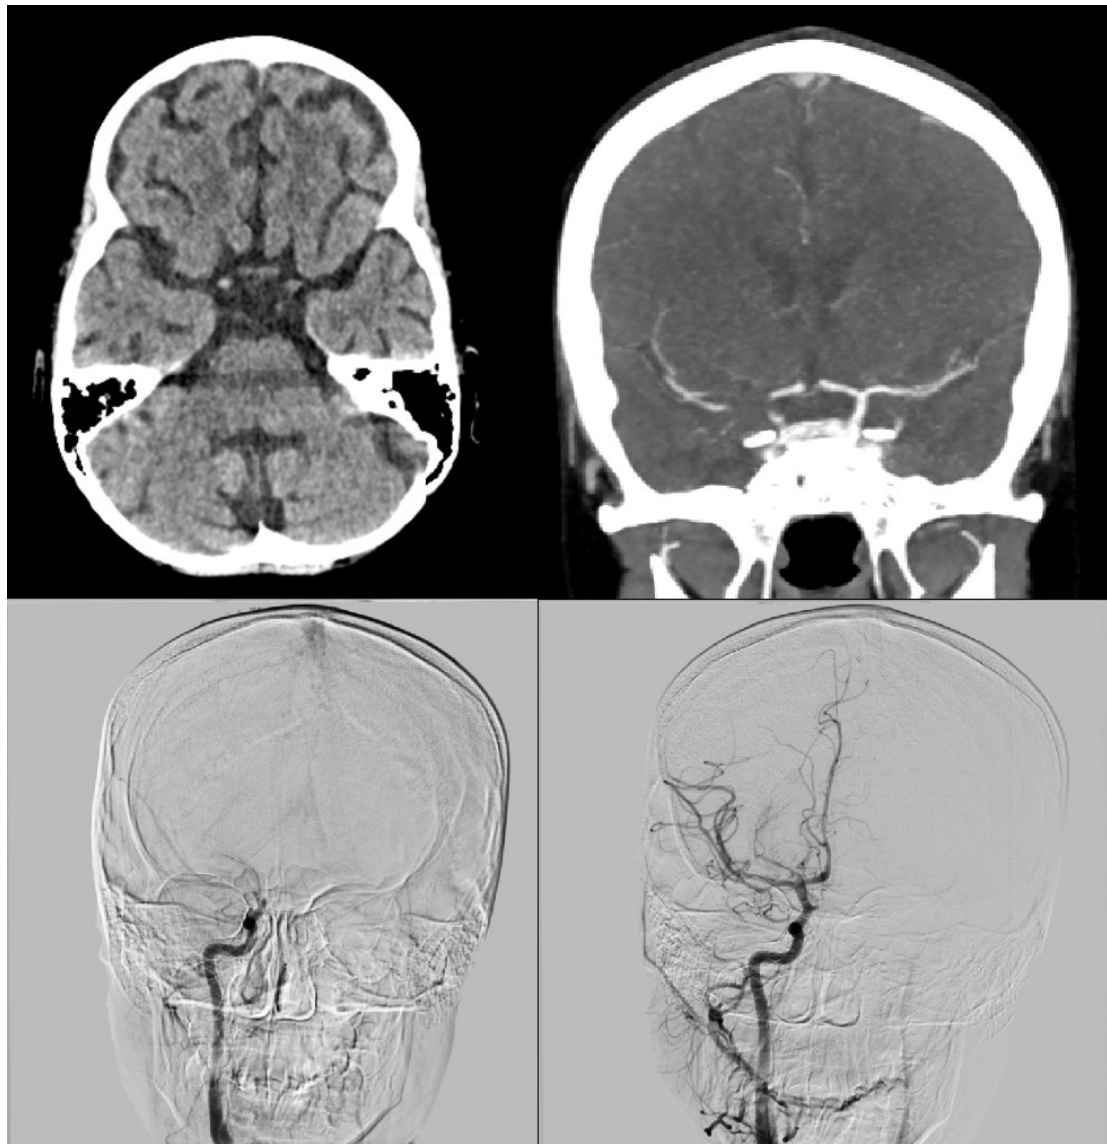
Mechanical thrombectomy procedure during ventricular assist device (VAD) support. Upper left: native computed tomography (CT) scan of the brain; Upper right: CT angiography of the brain; Lower part: before and after mechanical thrombectomy of the right middle cerebral artery.
